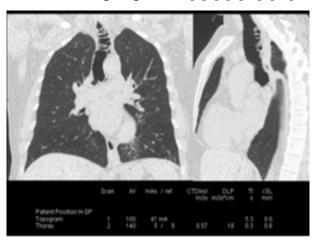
CT low dose, patient 41-year-old, BMI 26.5 kg/m², prolonged cough, present an abnormal at lower left lobe on Xray Chest. CT-DIvol 0.57 mGy and DLP 18 mGy.cm. Effective dose 0.3 mSv equals effective dose of a convention CR Chest AP [15]
